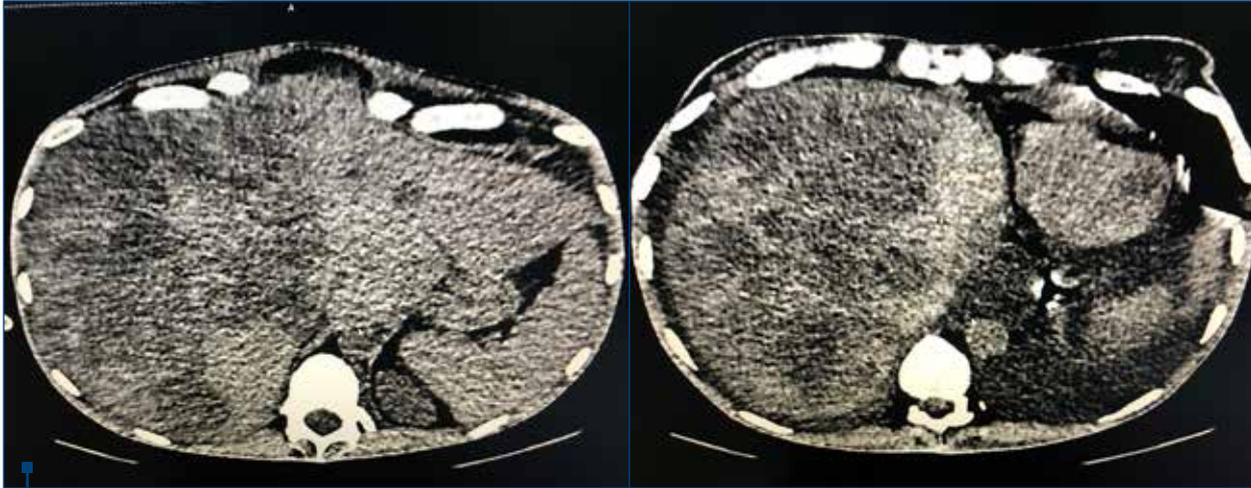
Abdominal CT without contrast
